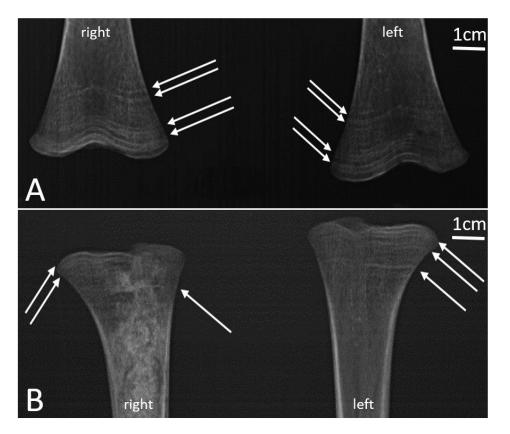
X-ray images of the proximal extremity of femora (A) and distal extremity of tibiae (B) showing the location of Harris lines (white arrows).
